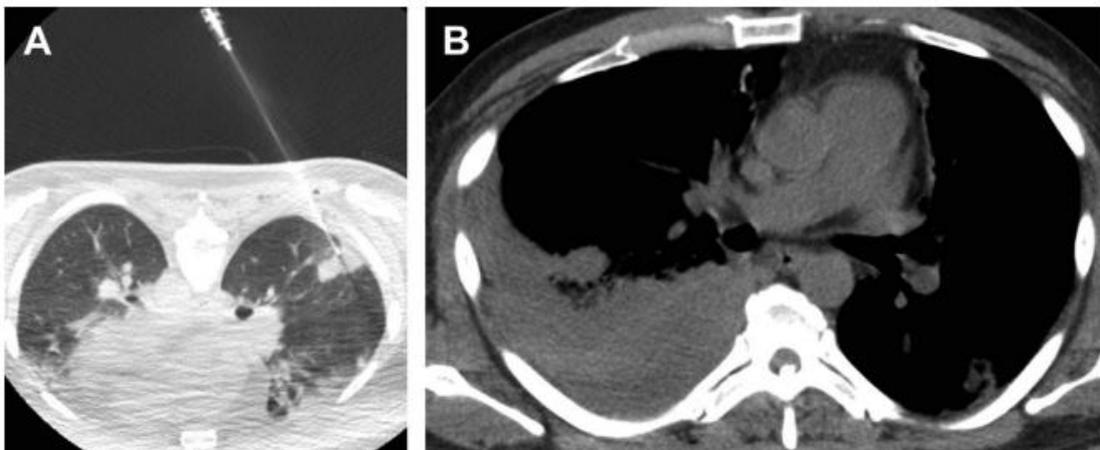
Axial CT scans of chest showing a 49-year-old man with acute myeloid leukemia and fungal pneumonia. (A) Prone axial lung window CT image during PTNB shows the tip of the coaxial needle in the nodule. (B) Immediately following removal of the coaxial needle the patient developed pleuritic chest pain. Chest CT done showed high-density fluid in the right pleural space secondary to hemothorax that required emergency drainage.
